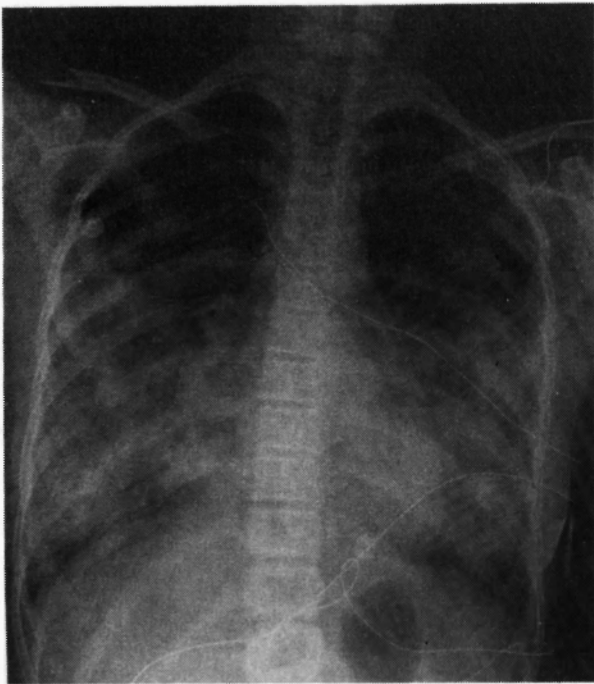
Chest X-ray. Bilateral mid and lower zone alveolar shadowing consistent with extensive pulmonary oedema.
